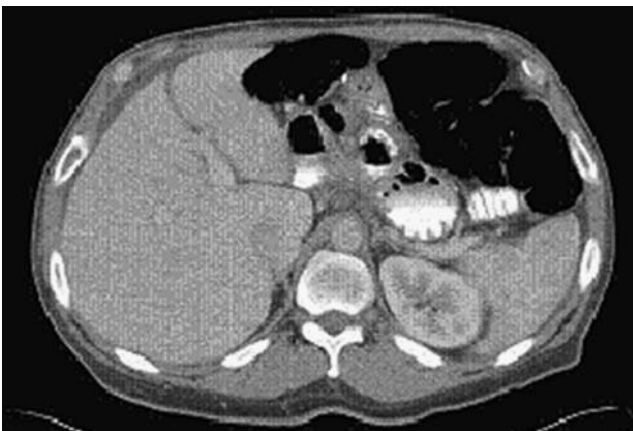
Abdominal CT with contrast showing small amount of fluid at liver, spleen, right paracolic gutter, and mesenteric adenitis
